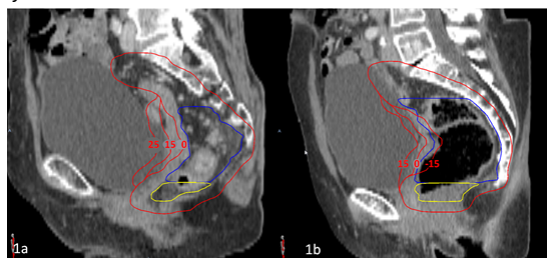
Margin sets based on anatomy as captured on planning CT. (1a) shows full rectum with a set of 25 mm, 15 mm, and 0 mm anterior margins (red) for upper mesorectum (blue). (1b) shows empty rectum with a set of 15 mm, 0 mm, and -15 mm anterior margins (red) for upper mesorectum (blue).
